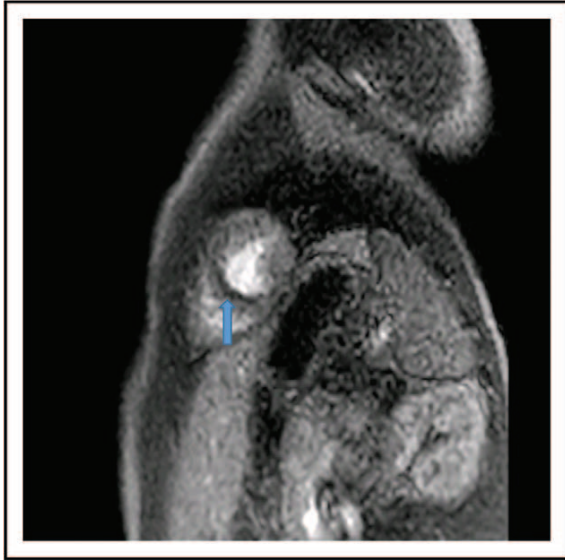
Cardiac magnetic resonance imaging with dobutamine stress demonstrating a subendocardial perfusion defect in the inferior septum (blue arrow) in a patient with anomalous right coronary from the left sinus of Valsalva. Printed with permission from Texas Children's Hospital not published © 2019.
